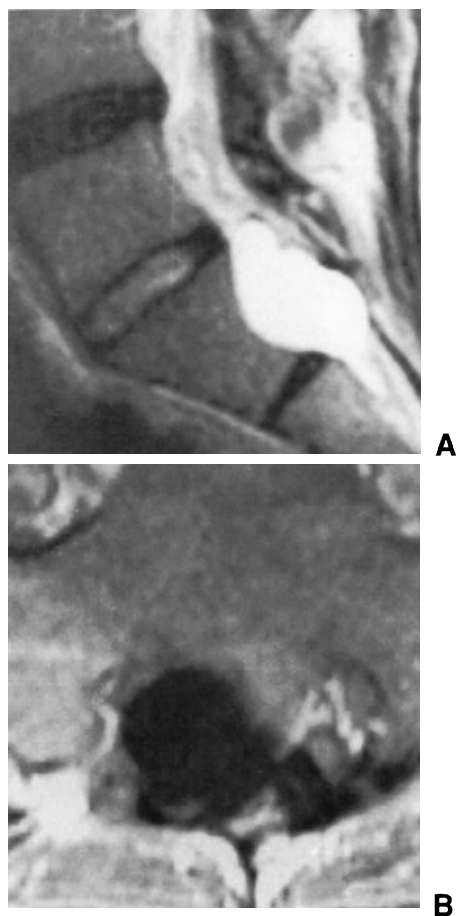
MRI appearance of large perineurial cyst at S2 level. (A) Sagittal turbo T2-weighted spin-echo image: the cyst displays a higher signal intensity than the CSF. (B) Axial T1-weighted spin-echo image: no nervous structures are visible within the cyst, which deforms the posterior wall of the thecal sac.
